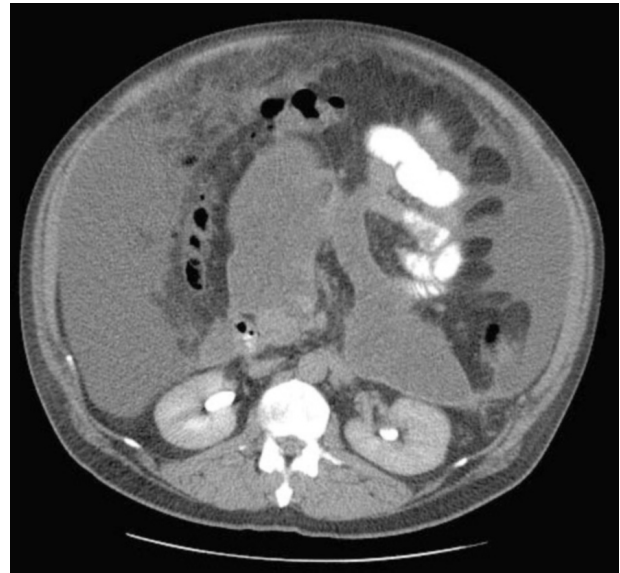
Single axial CT slice taken from series C, demonstrating the pseudocyst abutting the anterior surface of the psoas muscle in the region of the left ureter. The arrow indicates the region of interest in series C.
